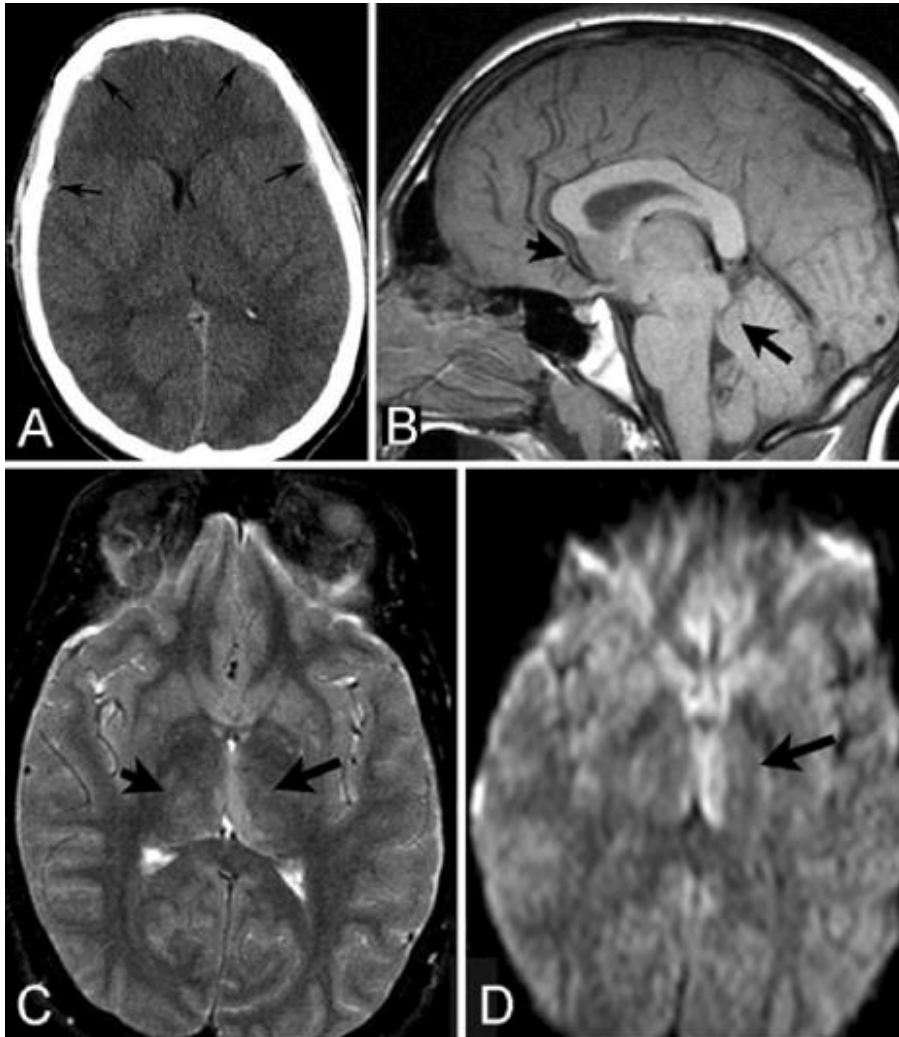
Picture from case in study by Weinstein et al. CT and MRI pictures were taken after second impact. A: head CT with arrows pointing to thin bilateral subdural hematomas. B: Sagittal T1 brain MR image with arrows pointing to downward descent of midline structures. C& D: Axial T2 MR image, arrows pointing to thalamic injury. Restricted diffusion was proven by calculation of apparent diffusion coefficient. (90)
